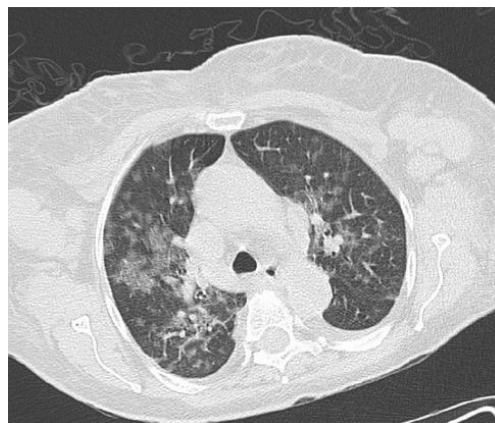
Chest CT scan showing bilateral ground glass opacities.
